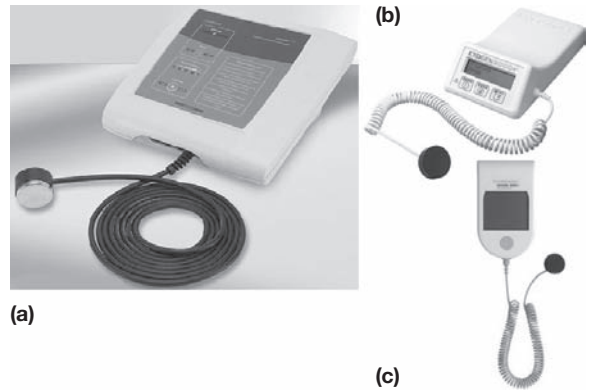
Ultrasonic Bone Growth Stimulators (a) Accusonic Lipus (b) Exogen 2000+ (c) Exogen 4000+
